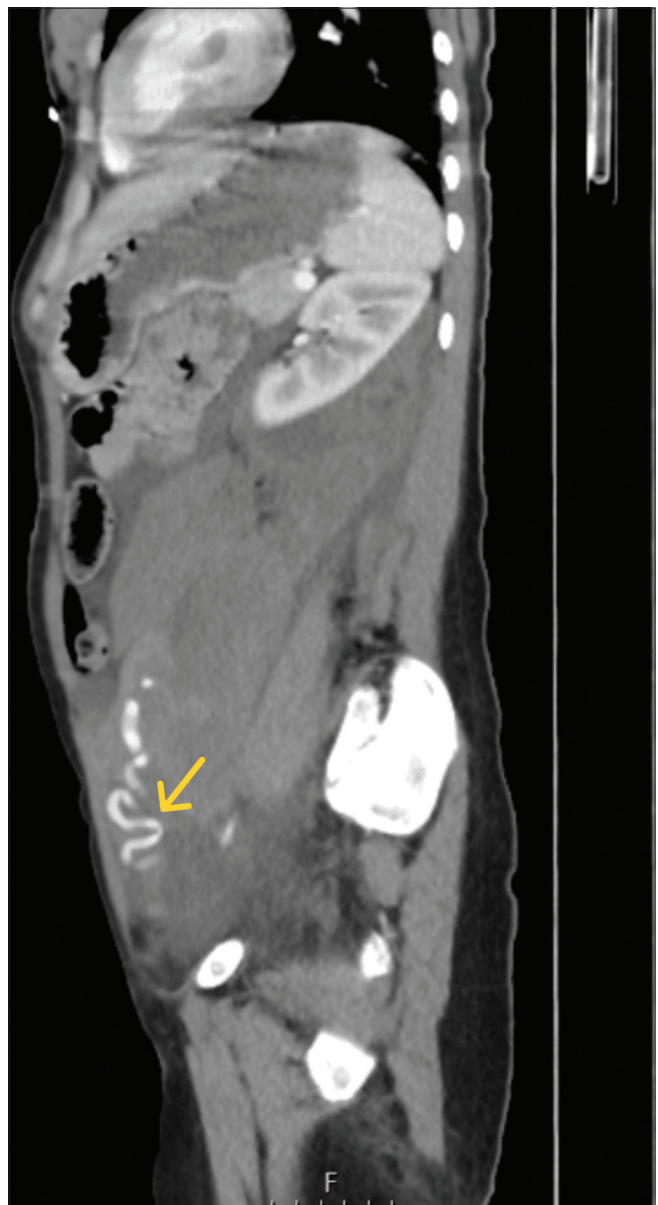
Sagittal view of computed tomography angiography demonstrating the tortuous left ovarian artery (arrow) within the hematoma
